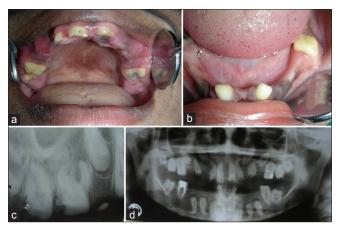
(Case 1) (a and b) Clinical image showing hypodontia in the maxillary and mandibular arch; also observe yellowish white smooth occlusal surface of the erupted teeth. (c) Intraoral periapical radiograph showing loss of enamel cap and lack of contrast between enamel and dentine. (d) Panoramic radiograph showing multiple impacted teeth, multiple pulp calcifications, and multiple acute dilacerations in the apical third of impacted and erupted teeth
